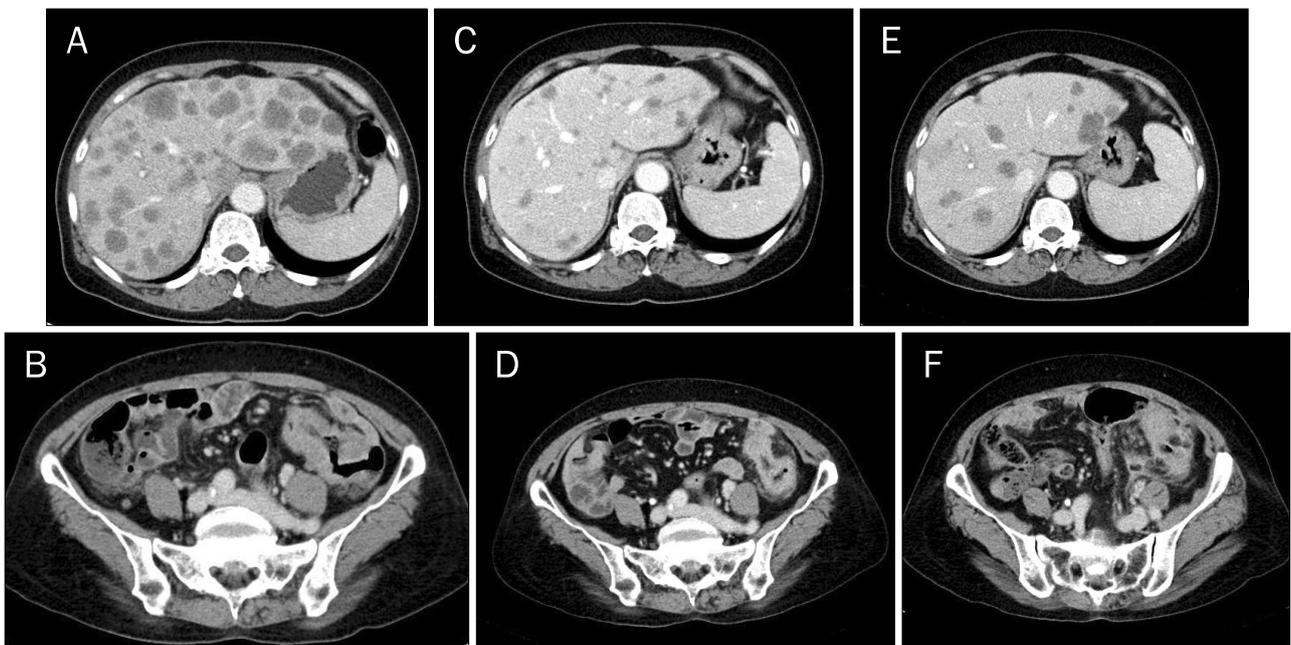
Abdominal CT findings. (A, B) Multiple liver metastasis with focal wall thickening of sigmoid colon (initial diagnosis). (C, D) Interval decrease in the size of liver metastasis and sigmoid colon cancer (after 4 months of FOLFIRI with bevacizumab chemotherapy: partial response). (E, F) Interval increase in the size of liver metastasis and sigmoid colon (after 9 months of FOLFIRI with bevacizumab chemotherapy: progressive disease).
